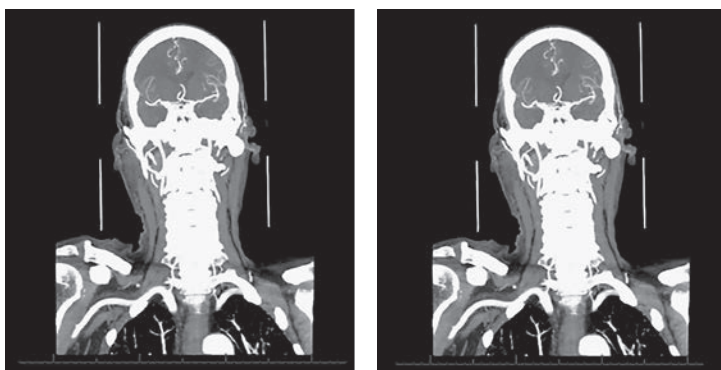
Computed tomography angiography of head and neck (maximum intensity projection images) showing decreased arterial density in the upper right cerebral arteries and, to a lesser extent, upper left cerebral arteries indicating decreased perfusion. This would suggest air within distal small arteries.
